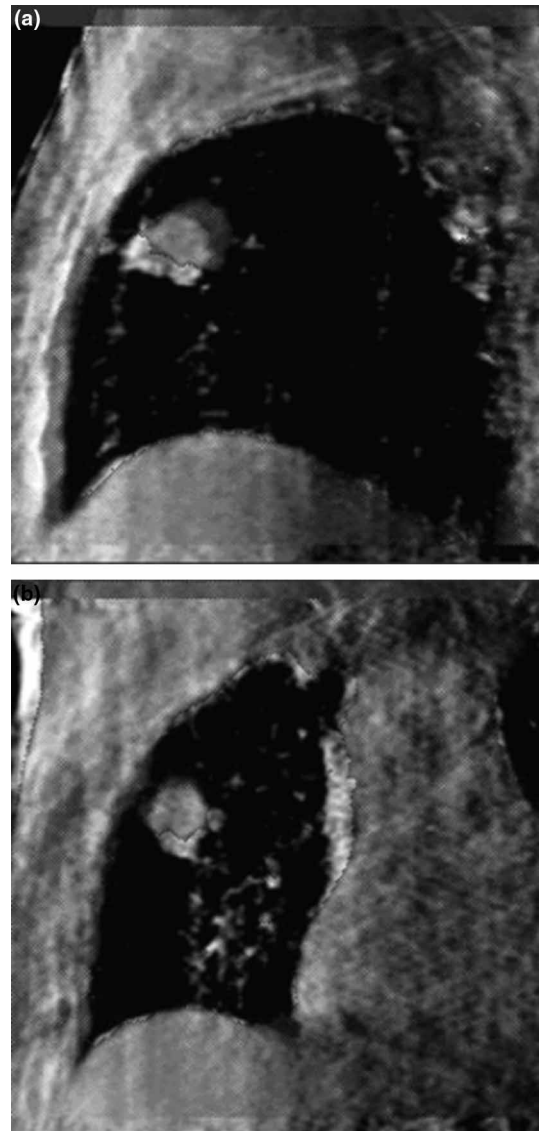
Respiration correlated CBCT images at maximum inspiration and maximum expiration for patient in Figures 1 and 3 in (a) sagittal and (b) coronal orientations.
